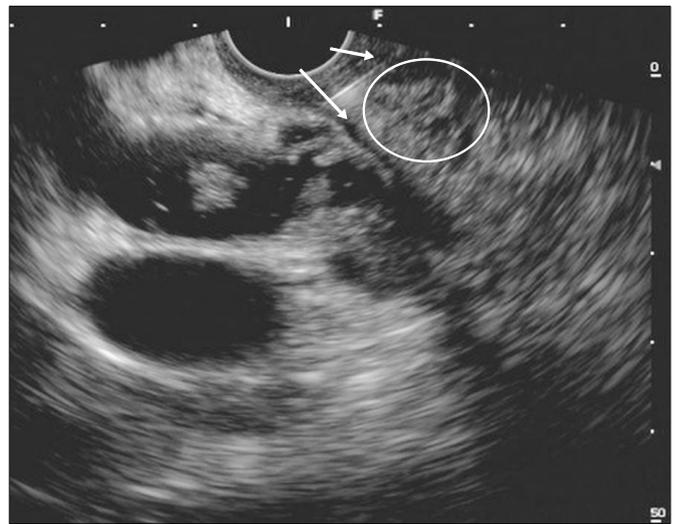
Endosonographic view of a mucosal double puncture. White arrows indicate the duodenal muscle layers, and other muscle layers are visible (white circle).
